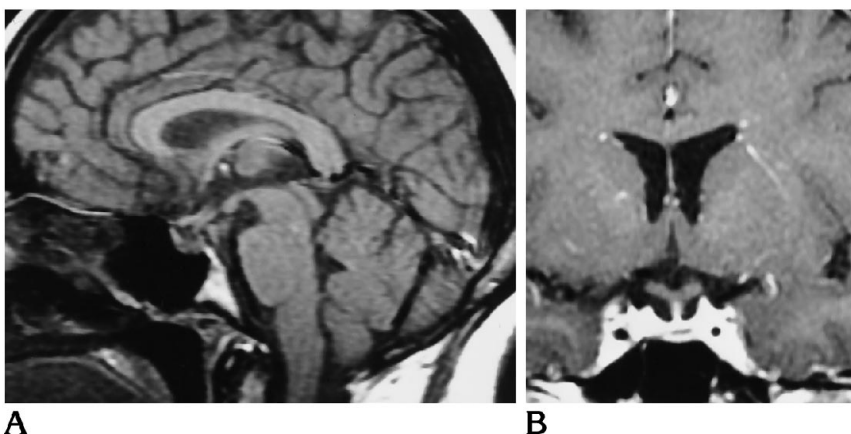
Sagittal (A) and postcontrast (B) T1-weighted images (370/12/2) after successful corticosteroid therapy show nearly complete resolution of sellar mass, infundibular thickening, and infundibular/hypothalamic enhancement.
